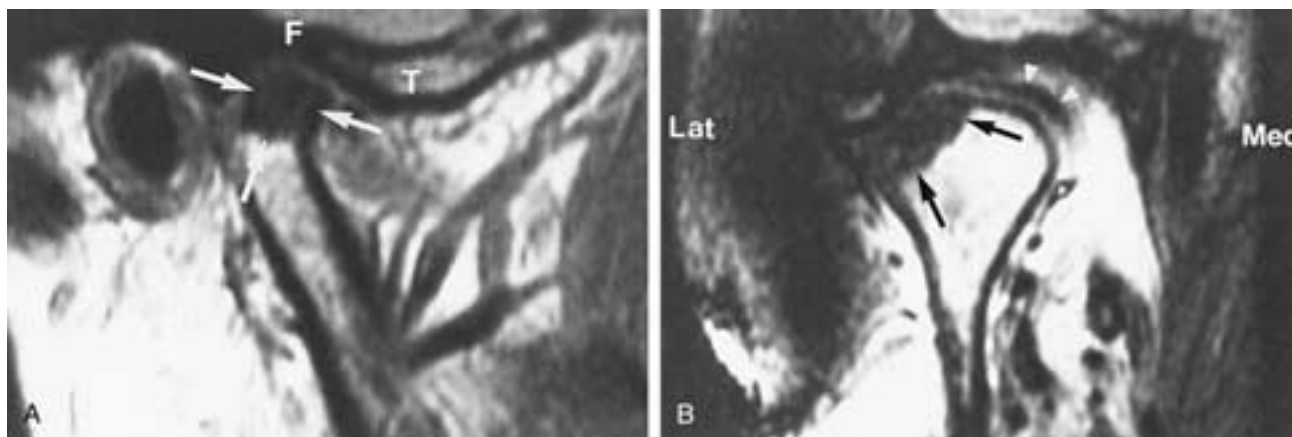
Probable aseptic necrosis. A, Sagittal MR image showing decreased signal from the bone marrow in the upper part of the mandibular condyle (*arrows*). The fossa (*F*) and tubercle (*T*) are indicated. B, Coronal MR image of the same joint as in A showing the low signal intensity area (*arrows*) in the lateral part of the joint. In the medial part of the condyle, the disk is seen superior to the condyle (*arrowheads*) and laterally the disk is absent, suggesting perforation.
